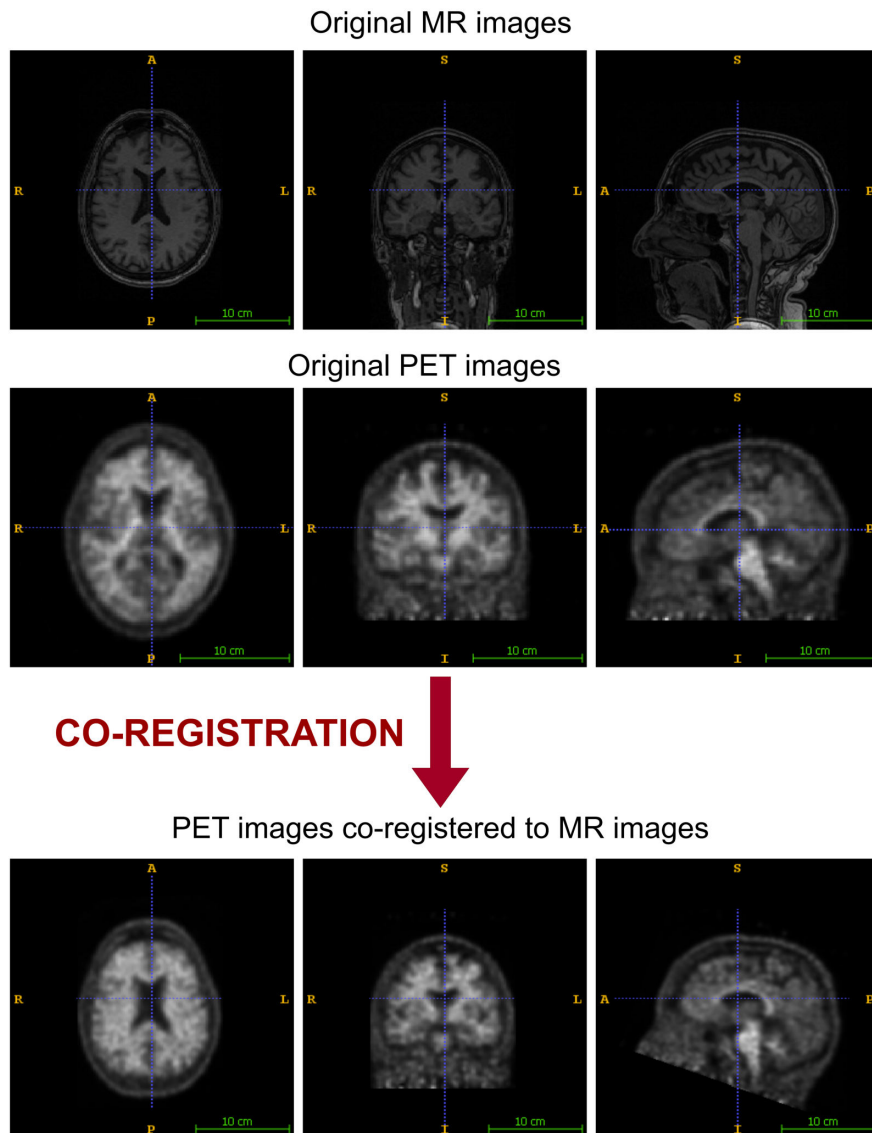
Example of a co-registration of 2 brain images from the same subject but different modalities: an amyloid PET image and a MR image. Images acquired at Hospital La Fe.
